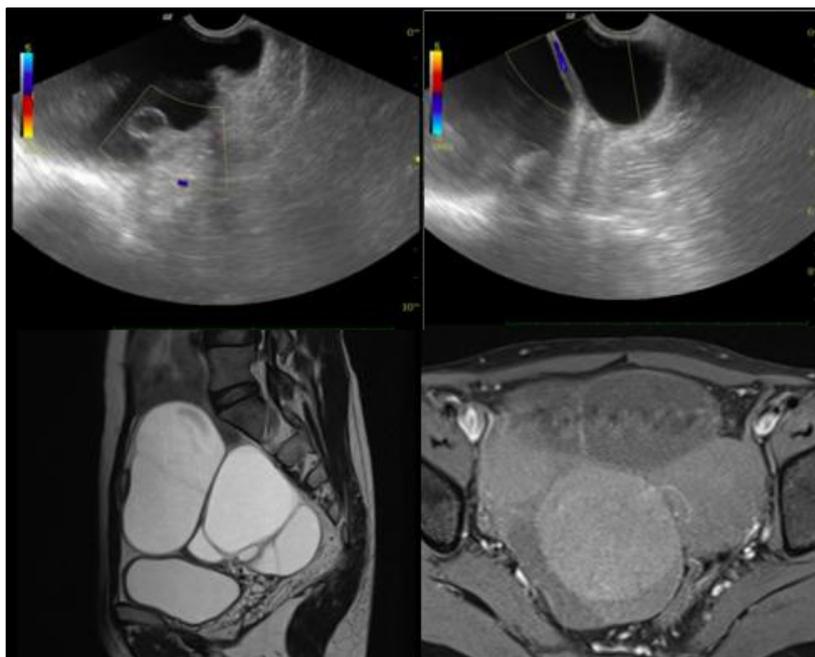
A 32 year female had complaints of diffuse abdominal pain and loss of appetite. USG Shows e/o well defined Multilocular Cystic Lesion with low level internal echoes and internal septations showing internal vascularity, seen in the right adnexa, possibility of Cystic Ovarian neoplasm could not be ruled out. MRI elicits, e/o well defined multilocular lesion in the right adnexa, which is hypointense on T1WI with fat suppression and hyperintense on T2W images, with internal septations. Diagnosed as Mucinous Cystadenoma Ovary
